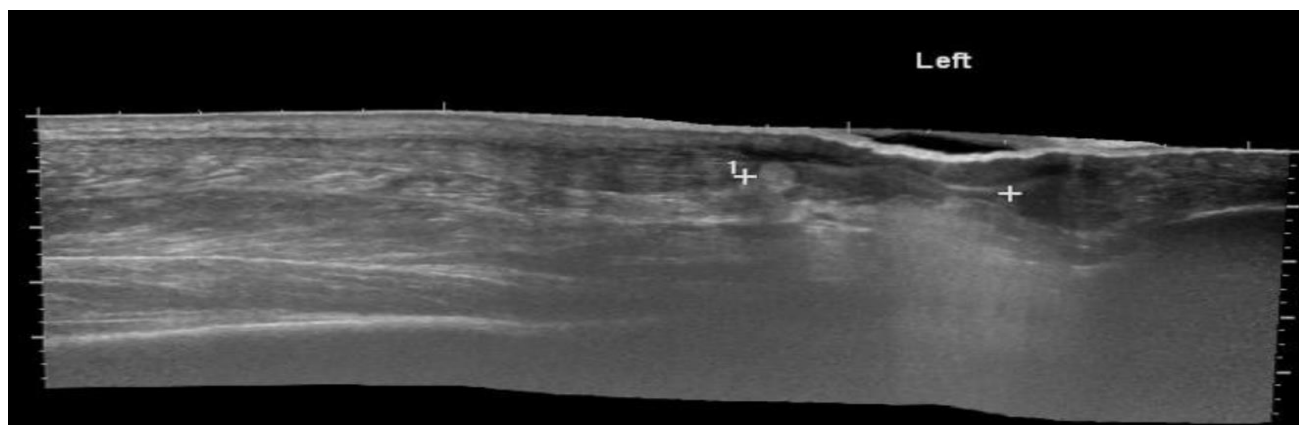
longitudinal grey scale ultrasound images of the Achilles tendon.^[29]
